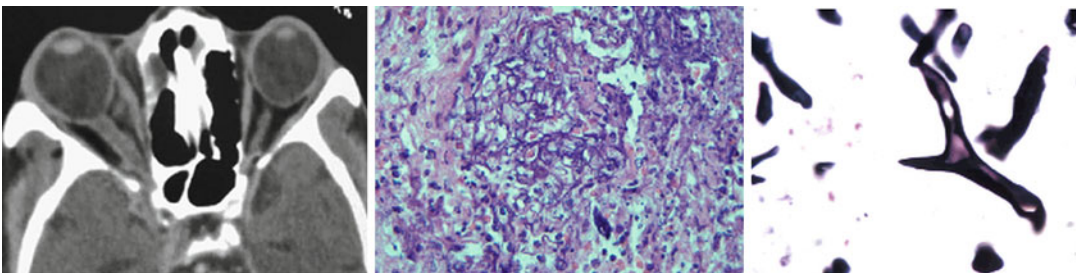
Mucormycosis causing an orbital apex syndrome in a diabetic patient with ketoacidosis who also abused alcohol. The patient presented with marked right ophthalmoparesis and loss of vision in the right eye. *Left*, axial CT scan shows thickening of the right optic nerve associated with abnormal tissue in the apex of the orbit
